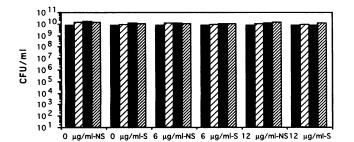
Concentration of viable *P. aeruginosa* in a 12-h culture subsequently exposed to gentamicin and/or ultrasonication. The x axis gives exposure to gentamicin and/or ultrasonication, where NS indicates no sonication and S indicates 67-kHz sonication. The bar shading represents subsequent exposure times as follows: black, 0 h; light hatching, 0.5 h; grey, 1 h; heavy hatching, 2 h.
